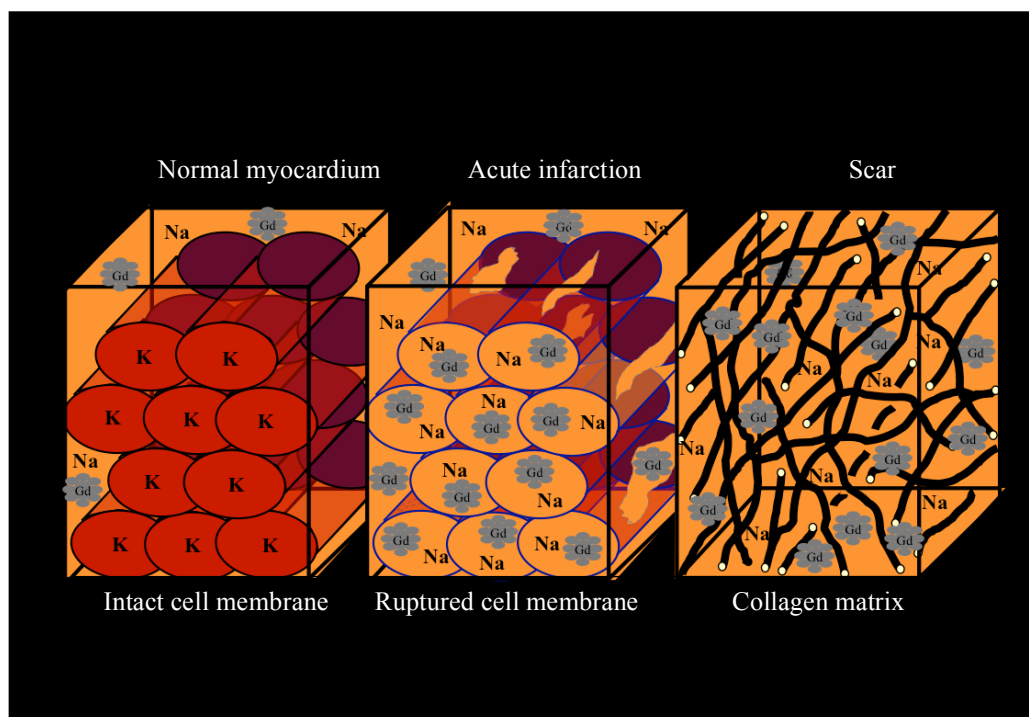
Potential mechanisms of hyperenhancement in acute and chronic myocardial infarction. Kim RJ, Choi KM, Judd RM, Higgins CB, de Roos A, eds. Cardiovascular MRI and MRA. Philadelphia, PA: Lippincott Williams and Wilkins; 2003: 209-237.
